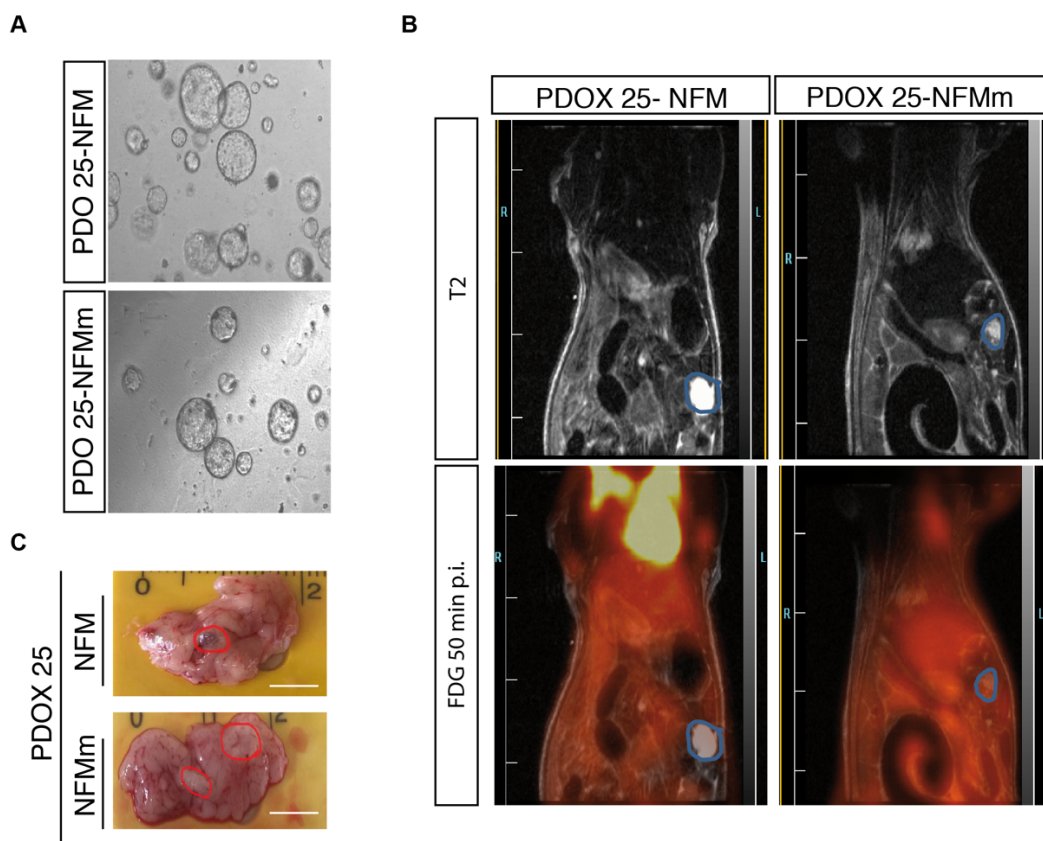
A. Representative phase contrast images of PDOs treated with NFM and NFMm. B. Monitoring of the tumor by PET/MRI imaging modalities. The upper panel shows the MRI images and the lower panel displays PET images. C. Macroscopic images of the PDOX.
